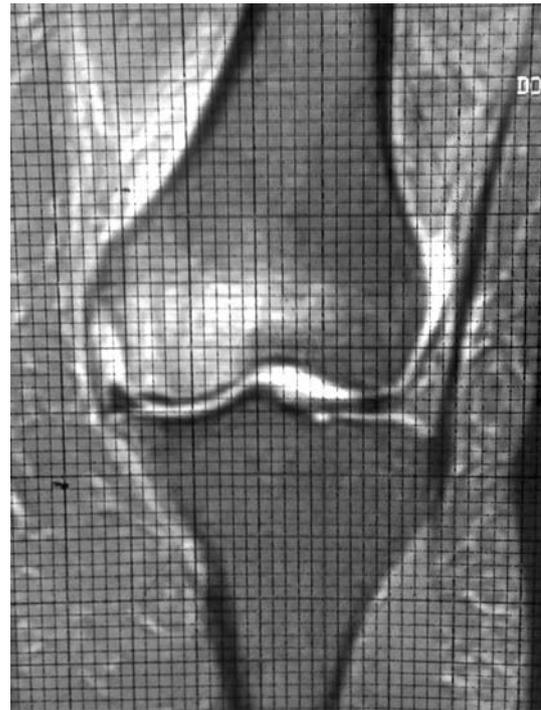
Edema measurement by MRI with 1 mm transparent measurement template
